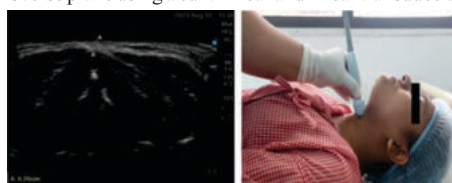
Ultrasound Measurement of ANS-VC: Distance from Skin to Thyroid Cartilage. Ultrasound Probe in Transverse Position
